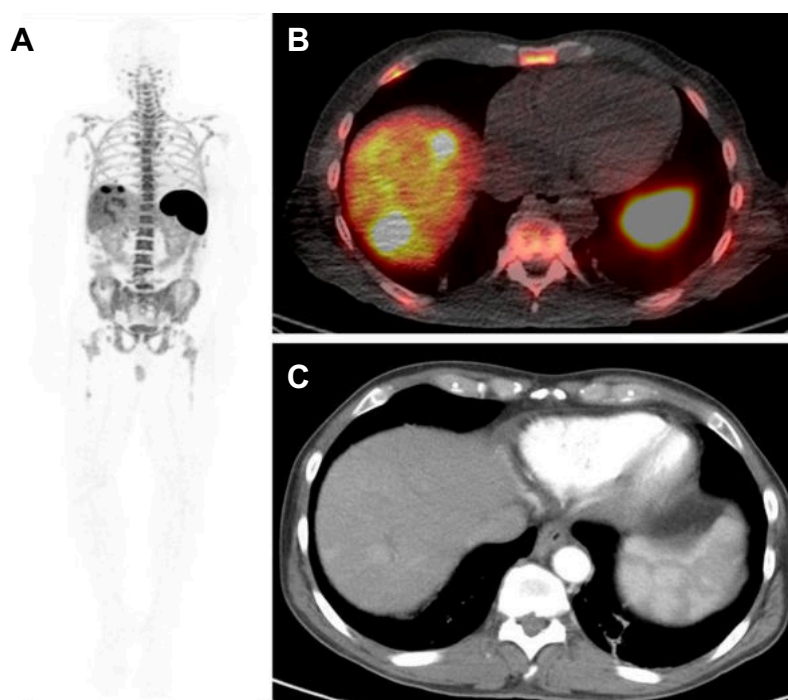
(A) 24 hour whole-body (MIP) image, (B) fused PET/CT image and (C) contrast enhanced CT of a patient with hepatocellular carcinoma injected with 0.5 mg $[^{89}\text{Zr}]\text{Zr-IAB22M2C}$. $[^{89}\text{Zr}]\text{Zr-IAB22M2C}$ -positive lesions are seen in 2 liver metastases and additional uptake is seen in 3 abdominal lymph node metastases. Figure copyright from [103].
